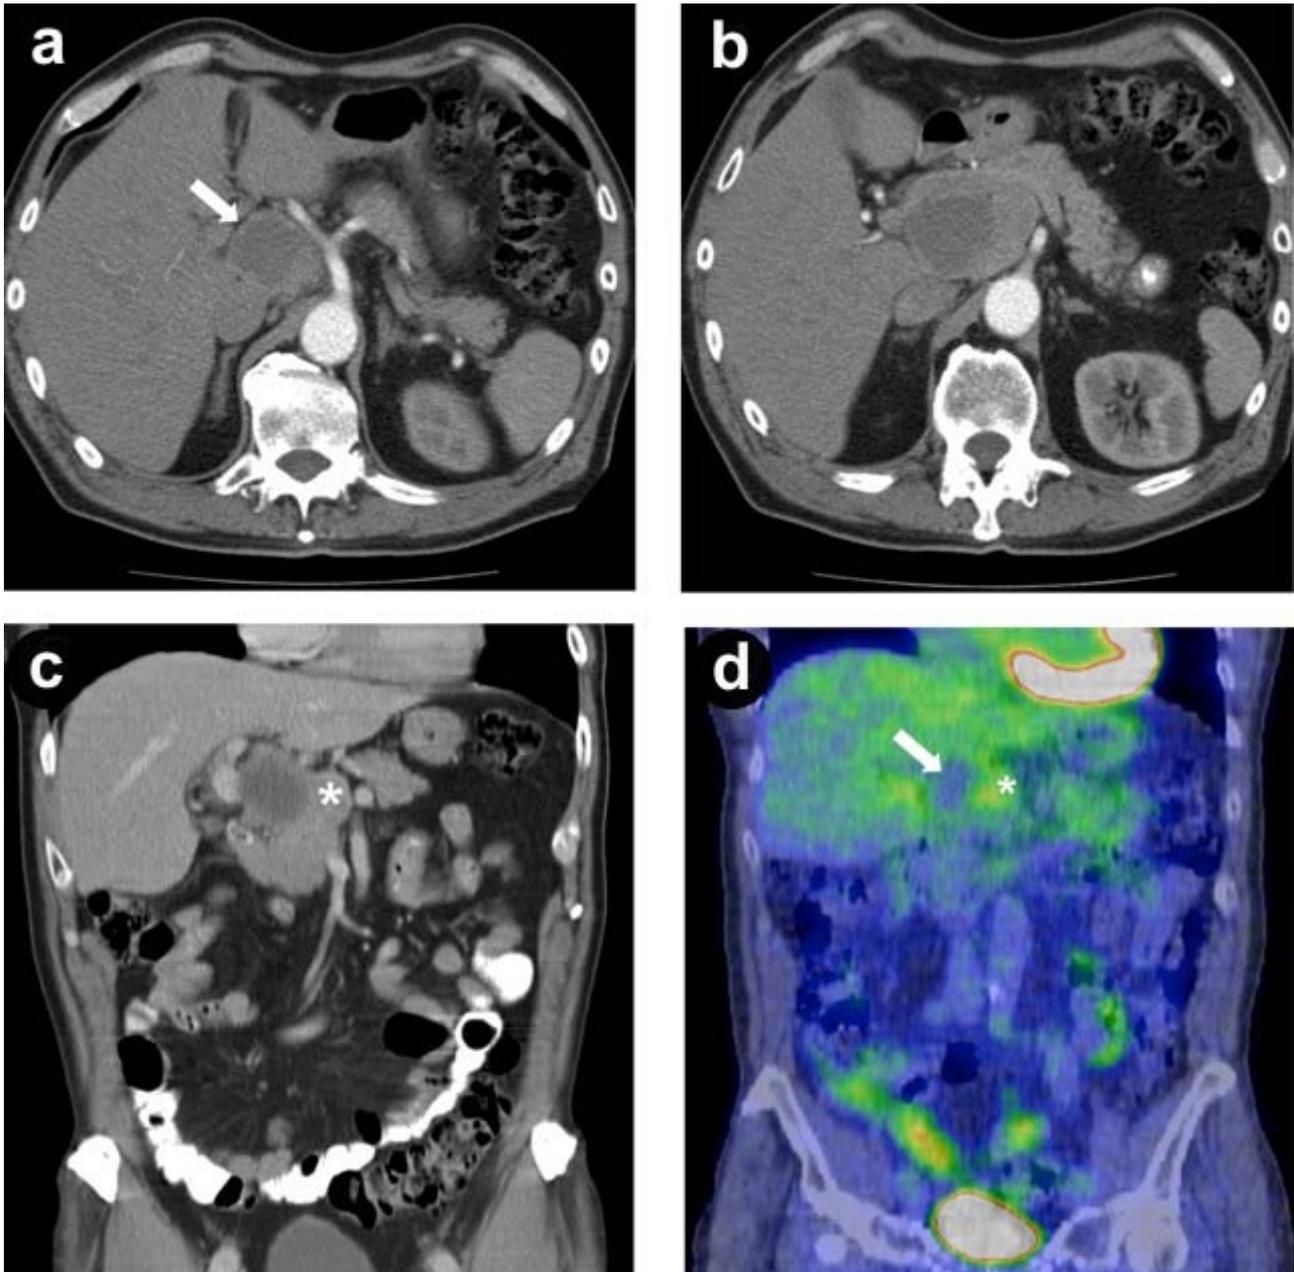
a. Arterial phase computed tomography showing in axial image a partially cystic pancreatic head mass (arrow) with celiac artery running adjacent to it. b. The mass extended into the uncinate process of the pancreas adjacent to the superior mesenteric artery. c. The mass seen on coronal reconstruction in porto-venous phase demonstrating cystic and solid (asterisk) components. d. Computer tomography positron emission tomography (CT-PET) showing no uptake within the cystic component (arrow) of the mass with mild increased uptake in the adjacent solid component (asterisk).
